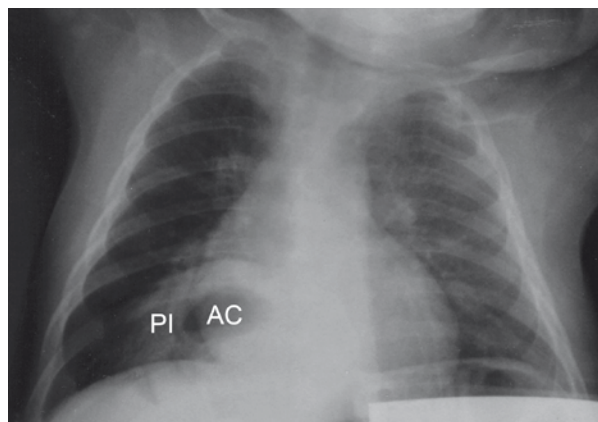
Initial thorax X-ray image. PI - suspected right side pneumonia infiltration; AC - suspected abscess cavity
